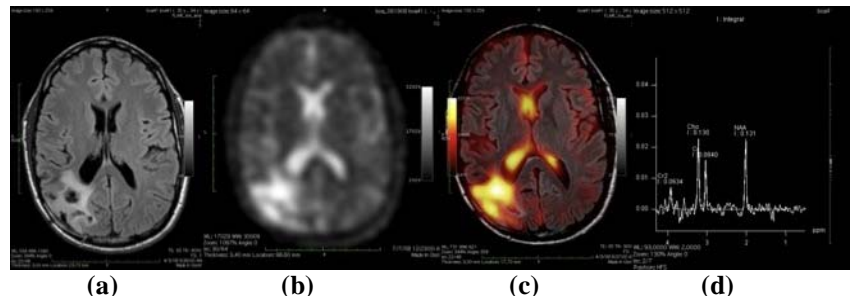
FLAIR, Sodium, fused and CSI images for a high-grade (anaplastic astrocytoma) brain tumor acquired at 3T.
